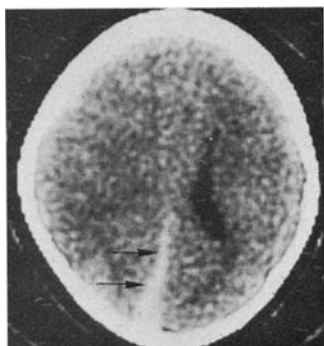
A 3-year-old girl with obtusion and unilateral flaccidity after an alleged fall. CT without intravenous contrast material shows a right parieto-occipital AIHSH (arrows). The right lateral ventricle is obliterated. Following discharge, left homonymous hemianopsia developed.
